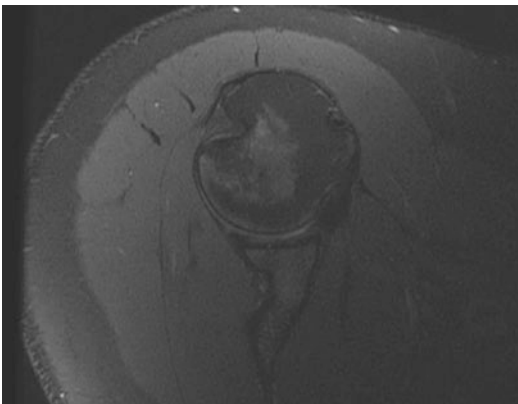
T2 axial MRI image demonstrating Hill-Sachs lesion
